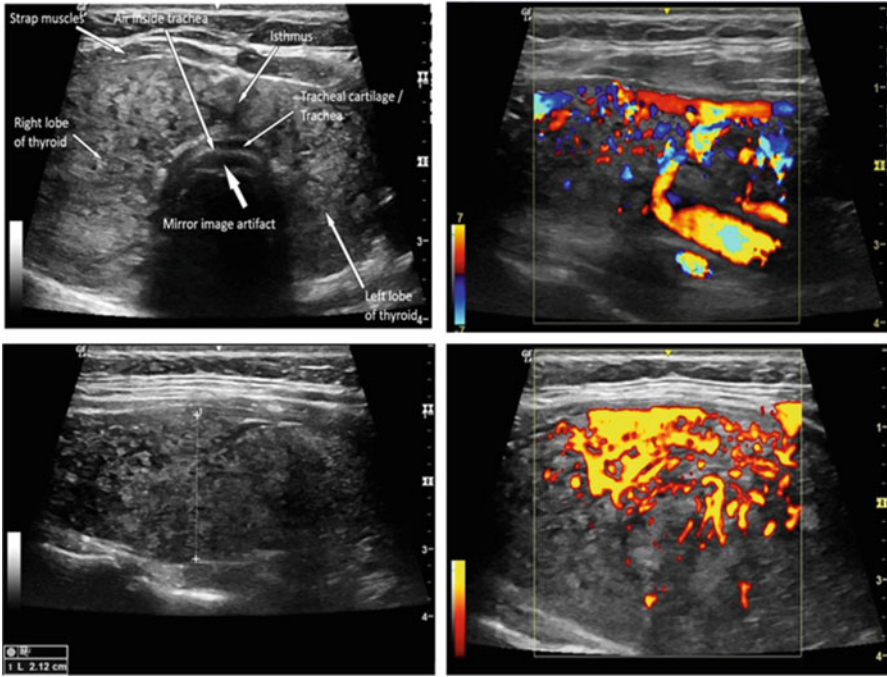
Thyroid gland of a patient with Hashimoto’s thyroiditis. Top: B-mode midline-transverse (left) view and long axis color flow Doppler (right). Bottom left: long axis of left lobe with measurement calipers, right: power Doppler. Color and power Doppler imaging shows marked hypervascularity
